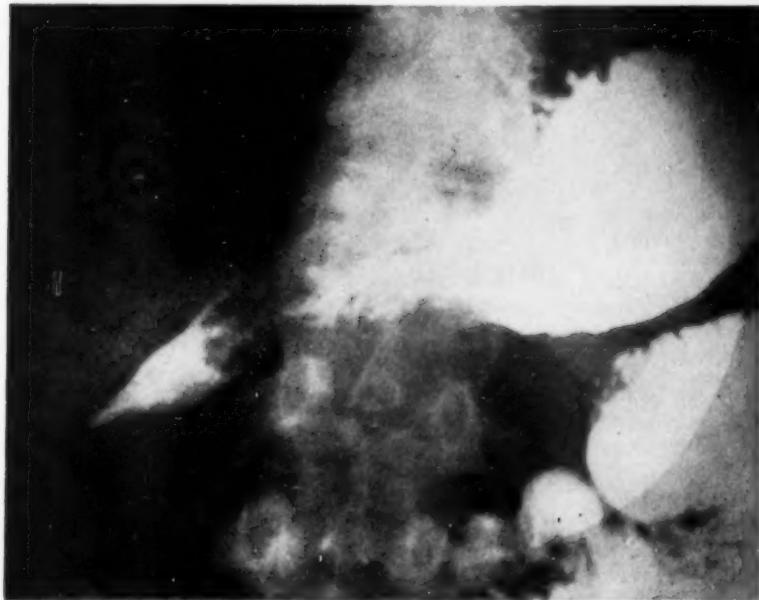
(*Case 1*) Preoperative x-ray demonstrating prolapse of the antral mucosa into the base of the duodenal bulb. At operation the degree of prolapse was considerably greater than that observed radiologically.
